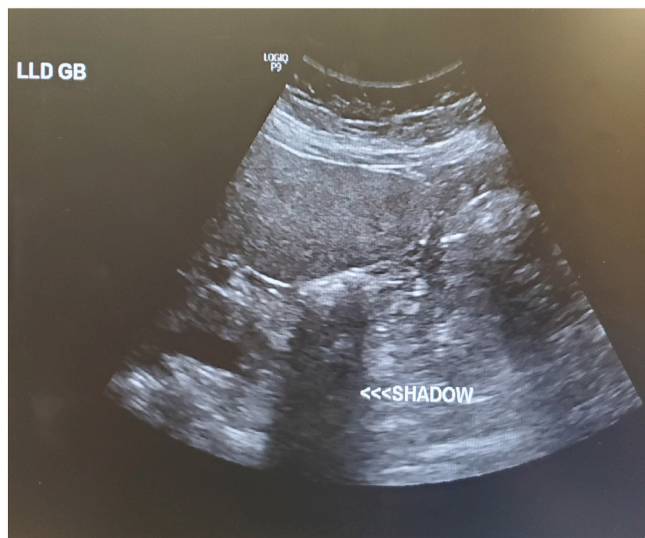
Abdominal ultrasound obtain preoperatively. Limited evaluation of the gallbladder due to wall shadow echo complex from gallstones filling gallbladder per radiology report.
